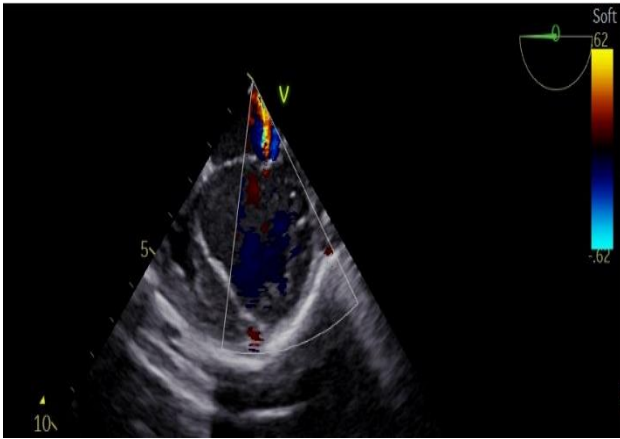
Modified mid esophageal 4-chamber TEE view (0 degree); color-Doppler revealed a mild MR after removal of the aortic cannula (labeled).
